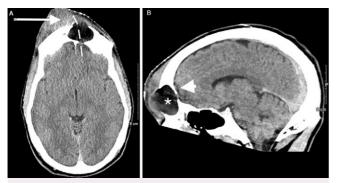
CT scans performed preoperatively. A: Enlargement of the right frontal soft tissue swelling consistent with known PPT ruptured through the skin (*arrow*) with demonstration of the connection between the epidural space and ruptured abscess collection indicating an ECF (*dashed line*). B: Frontal mucocele appears more enlarged and bulging through the anterior wall defect (*asterisk*), and a small epidural fluid collection posterior to the frontal sinus is seen (*arrowhead*).
